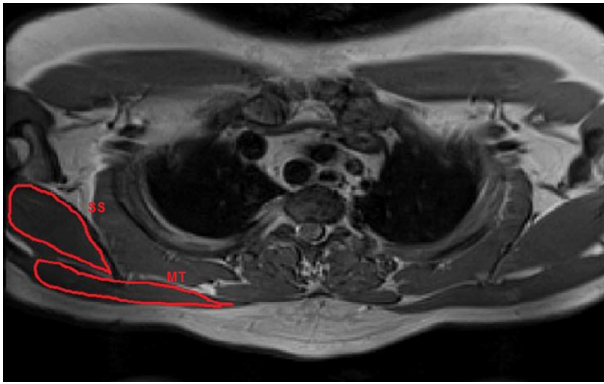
Region of interest (red outline) for the supraspinatus (SS) and middle trapezius (MT) muscles in the T2-weighted (T2 map) image at the level parallel to T2-T3.
